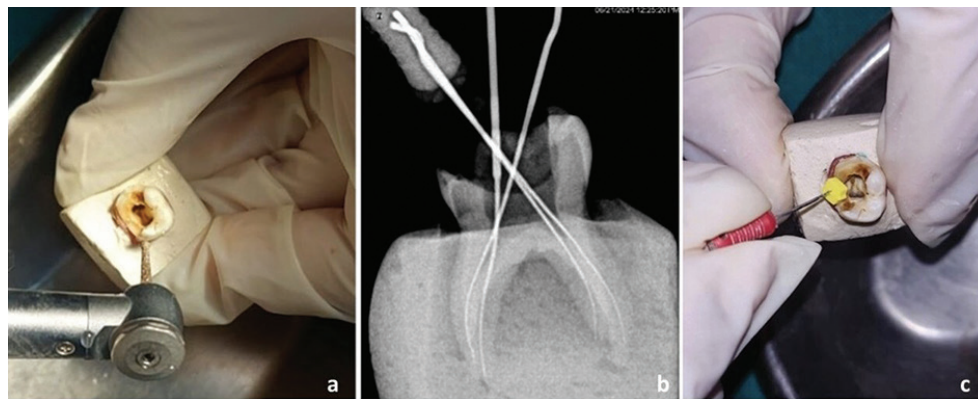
Root canal preparation (a) access opening using high-speed airtoror; (b) working length determination using radiographic technique; (c) shaping and cleaning of canals using k-files.
